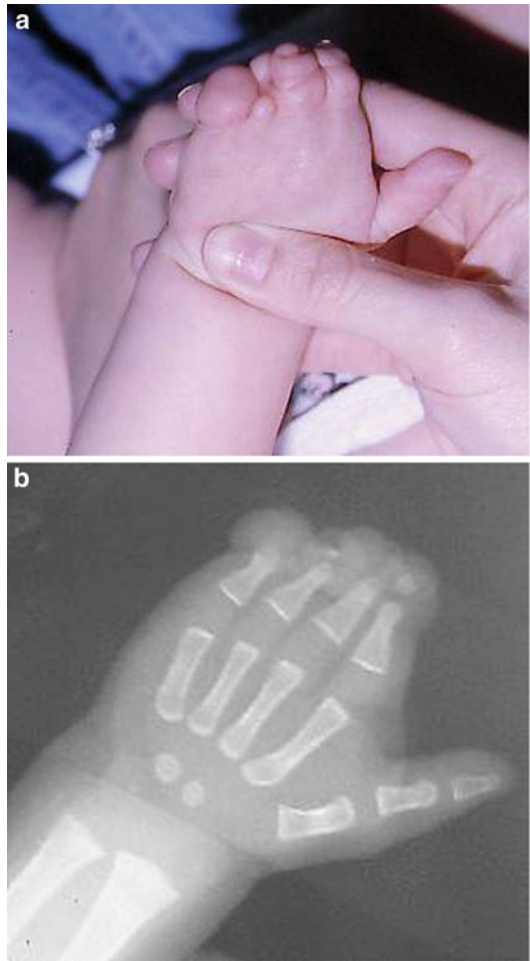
(a, b) A hand of an infant with constriction bands of the fingers with amputations, shown by the radiograph
